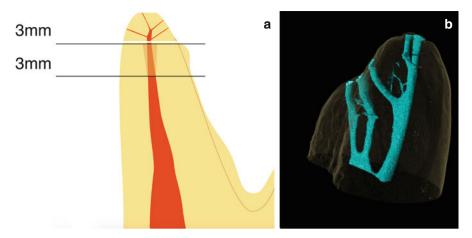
(a) "Rule of threes": The goal is to remove the apical 3 mm of each involved root by the apicoectomy and another 3 mm of the canal is instrumented and sealed by the retrofill. The final 6 mm of the canal is treated to eliminate or block most frequent communications at the apical third area between main canal and the periodontium. (b) Micro-computed tomography rendering of the mesiobuccal apex of a maxillary molar with multiple apical ramifications, indicating the complex anatomy that may be present in the apical portion of any molar root (Image B courtesy of Dr. O. Peters)
